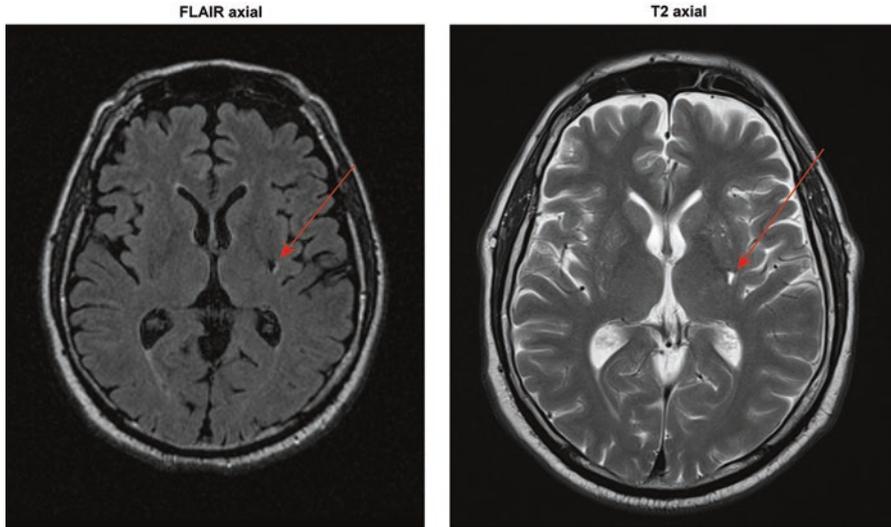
FLAIR and T2 axial MRI brain slices of patient with putaminal stroke
